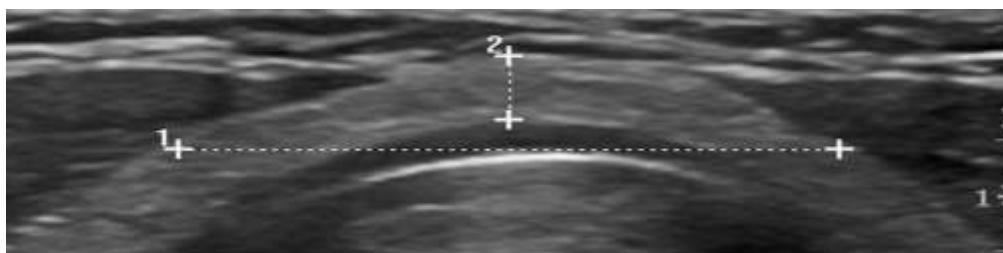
Transverse Scan, B-mode sonogram showing measurement of the transverse (calliper1) and anteroposterior (caliper 2) dimensions of the thyroid isthmus (Malago et al., 2008)
